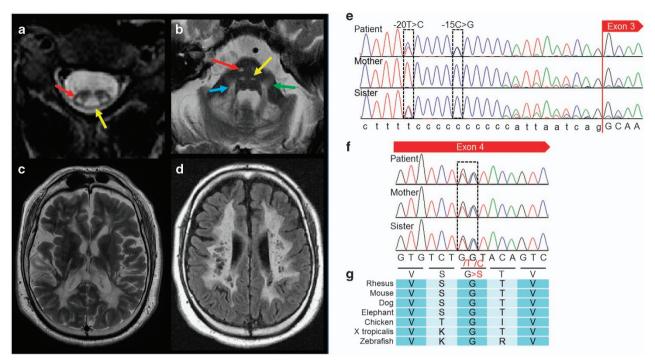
Radiological findings and results of molecular analysis. (a-d) Axial magnetic resonance images examined at 27 years. T2-weighted axial images (a-c) and a fluid-attenuated inversion recovery image (d). (a) In the spinal cord, the posterior columns (yellow) and the lateral corticospinal tracts (red) are involved. (b) At the level of the pons, high signal intensity is shown in bilateral lesions in the pyramidal tracts (red), medial lemniscus (yellow), superior cerebellar peduncles (blue), and intraparenchymal trajectory of the trigeminal nerve (green). (c) At the level of the basal ganglia, the posterior limb of the internal capsule and periventricular white matter are affected. (d) High signal intensity is shown in the periventricular white matter associated with multiple small cysts. (e, f) Electropherograms of Sanger sequencing for the patient, his mother, and the sister. Although a c.228-20T > C polymorphism is shown in both the patient and his sister (e), c.228-15C > G is only present in the patient. c.358_359delinsTC (p.Gly120Ser) is commonly shown in all samples (f), and the affected amino acid is conserved among species (g).
